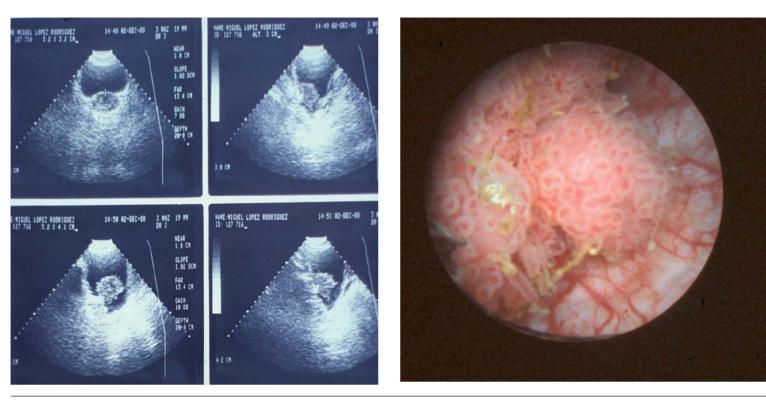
Bladder cancer: Exophytic tumor localized in the lateral wall. A. Ultrasonography excam. B. Cystoscopic view.
